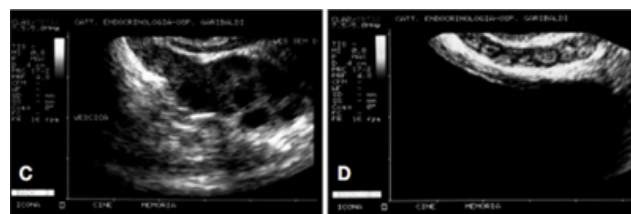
Dilated seminal vesicle vs. seminal vesicle with reduced thickness [27]; On the left dilated seminal vesicle with increased anteroposterior diameter (threshold: 14 mm) and polycyclic intraluminal areas. On the right seminal vesicle with a reduced anteroposterior diameter (threshold value: 7 mm) and inhomogeneous intraluminal space. The image on the left represent an ultrasound sign of "hypertrophic-congestive MAGI" associated with possible improvement of sperm parameters after therapy. On the right the image represent an ultrasound sign of "fibro-sclerotic MAGI" generally not associated with significant modification of sperm parameters after pharmacological treatment.
